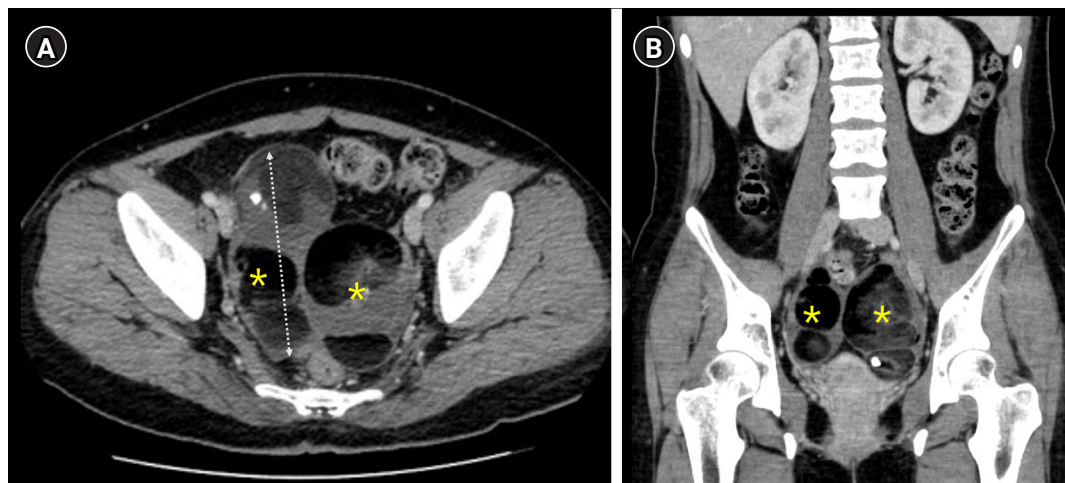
Abdominal-pelvic computed tomography demonstrating bilateral mature cystic teratomas occupying the pelvic cavity. (A) Axial computed tomography (CT) image showing bilateral cystic masses (asterisks) with internal heterogeneous components, measuring approximately 14 cm in diameter (dashed line). (B) Coronal CT image demonstrating bilateral pelvic masses (asterisks) causing mass effect within the pelvic cavity.
